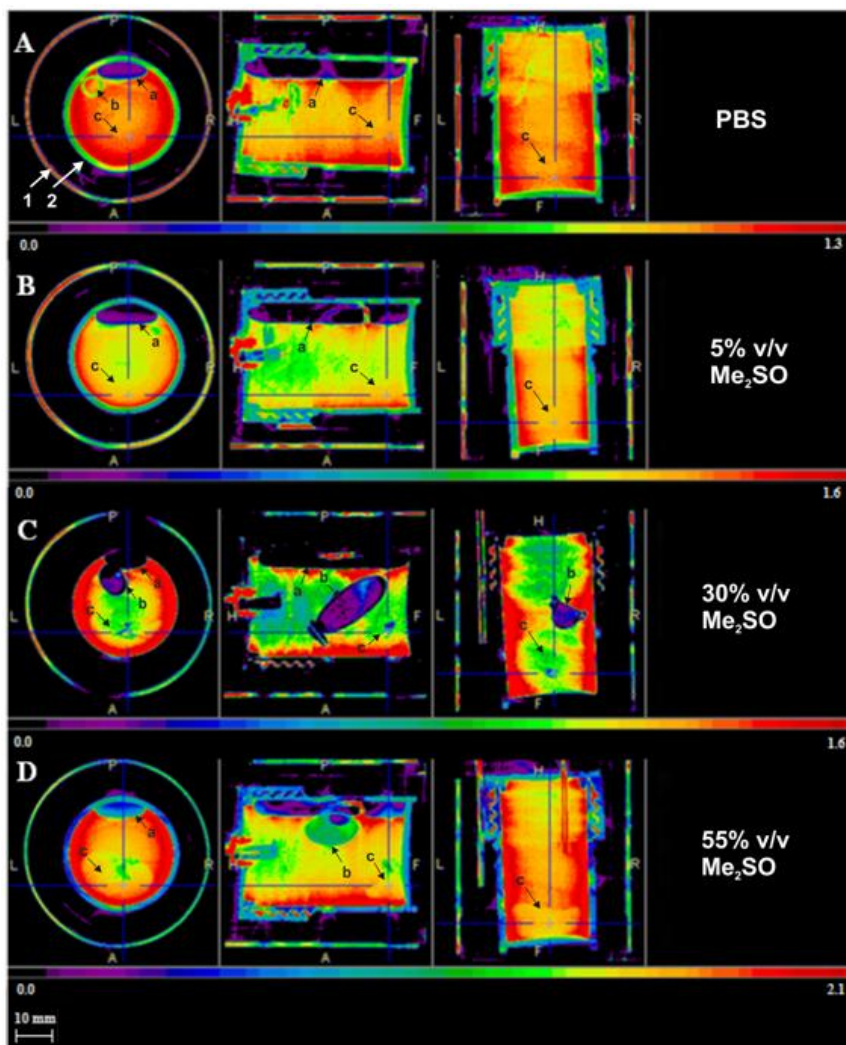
CT image of the 3 orthogonal views of kidney and Eppendorf with water immersed in different Me_2SO solutions in PBS, in a 30 ml PP vial at 20 °C. The kidneys were equilibrated with the concentration of the solutions for 9 days. The solutions correspond to: (A) 0% v/v (PBS), (B) 5% v/v, (C), 30% v/v and (D) and 55% v/v of Me_2SO in PBS. The CT image uses the cold scale and the spatial resolution is 200 μm
